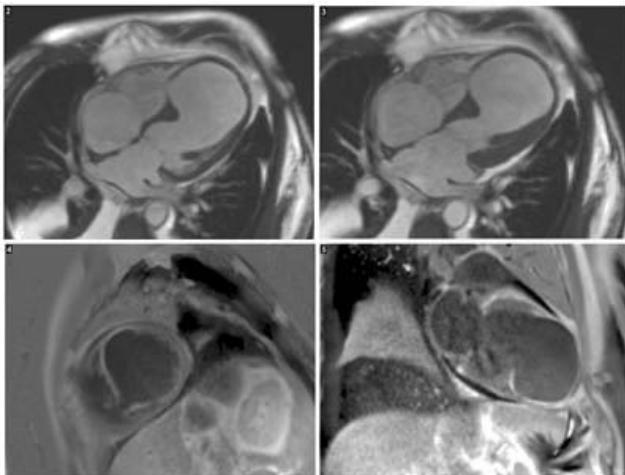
Cardiovascular magnetic resonance imaging of the aneurysmal LV with a VSD
